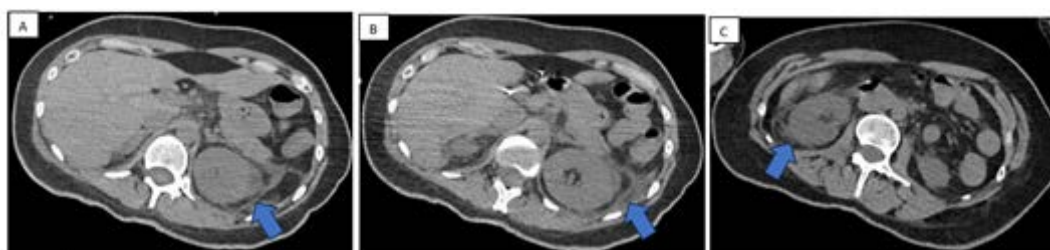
(A-C) A 55-year-old female patient, extracted from under debris and brought to our hospital 32 hours after the earthquake. Due to elevated blood creatinine levels, a non-contrast multidetector computed tomography examination was performed. The obtained images revealed the presence of hematomas (blue arrow) consistent with renal injury in the perirenal fat tissue around both kidneys.
